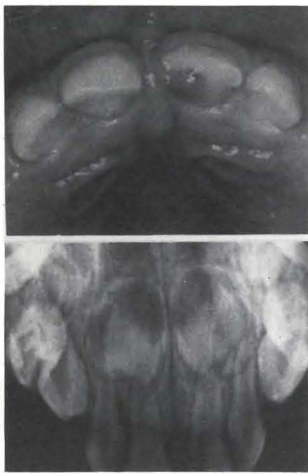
Clinical observations: S.H., eighteen-month-old girl struck tooth F on sidewalk. Tooth was mobile, sensitive to percussion and palpation, with Class III Ellis fracture. Clinical photo shows vertical crown fracture, and radiograph shows root fracture. The tooth was extracted two days after trauma.
